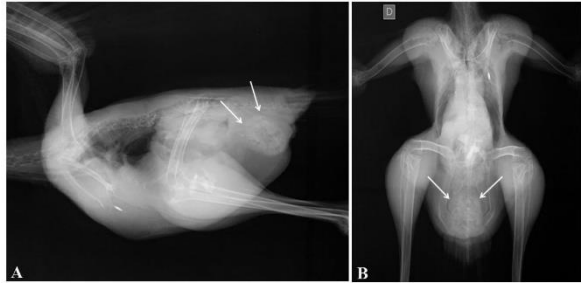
Lateral (A) and ventrodorsal (B) radiographs of a black-legged seriema. The cloacolith is visible in caudal coelomic cavity. Observed as increased soft tissue density (arrows).
